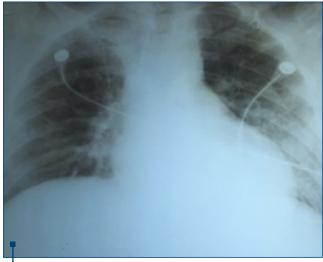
Chest X-ray showing left lower lobe opacity with alveolar pattern
